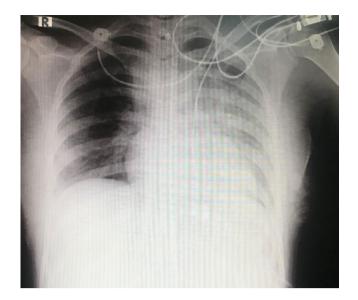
Patient chest X-ray
